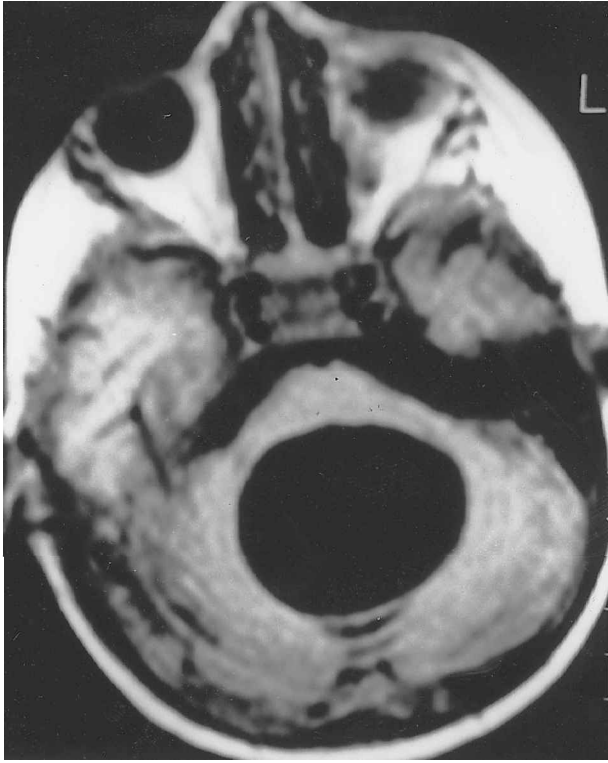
Unenhanced T1-weighted axial magnetic resonance imaging scan of case 2 show a large hypointense posterior fossa cystic lesion. The brain stem and fourth ventricle were compressed.
